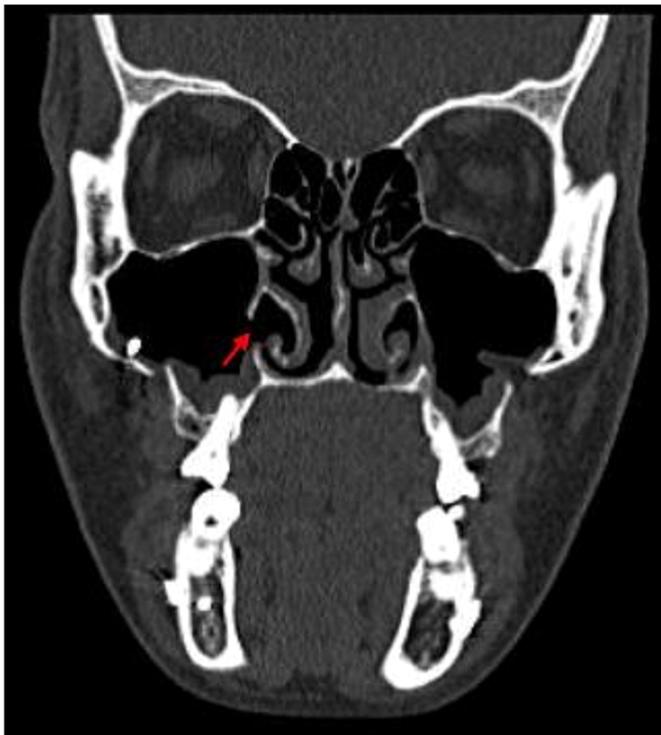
Postoperative coronal CT image showing unilateral accessory maxillary ostium in the right side of the medial sinus wall (arrow).
